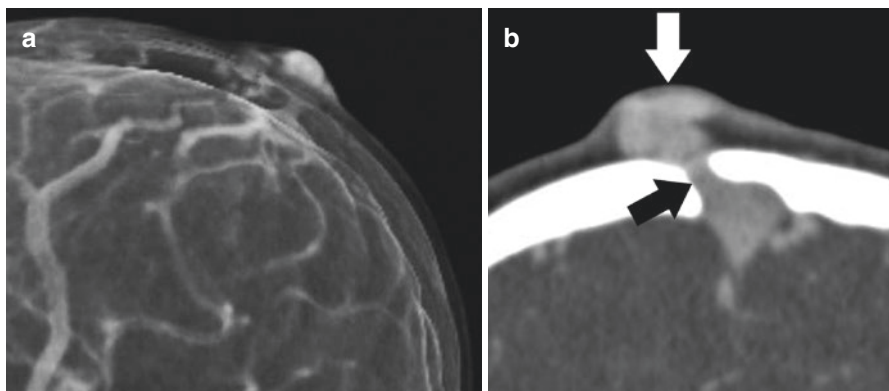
Six month old with parietal sinus pericranii. (a) Lateral view of a volume-rendered 3DCT reconstruction shows an epicranial pouch and an osseous channel in the subjacent parietal calvarium. (b) Coronal CT angiography shows the epicranial venous pouch (*white arrow*) to communicate directly with the superior sagittal sinus through the calvarial defect (*black arrow*).
